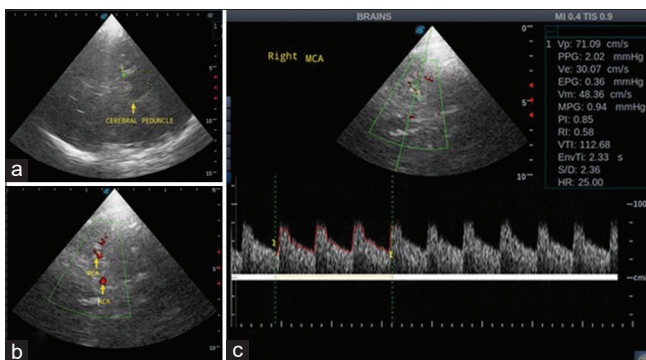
Transcranial colour Doppler B mode, colour and spectral Doppler images. The hypoechoic butterfly shaped cerebral peduncle is outlined on the B mode image (a). On colour Doppler, the MCA and ACA are demonstrated (b). The Vm and PI were obtained from the spectral Doppler waveform (c). MCA: Middle cerebral artery, ACA: Anterior cerebral artery, Vm: Mean velocity, PI: Pulsatility index
